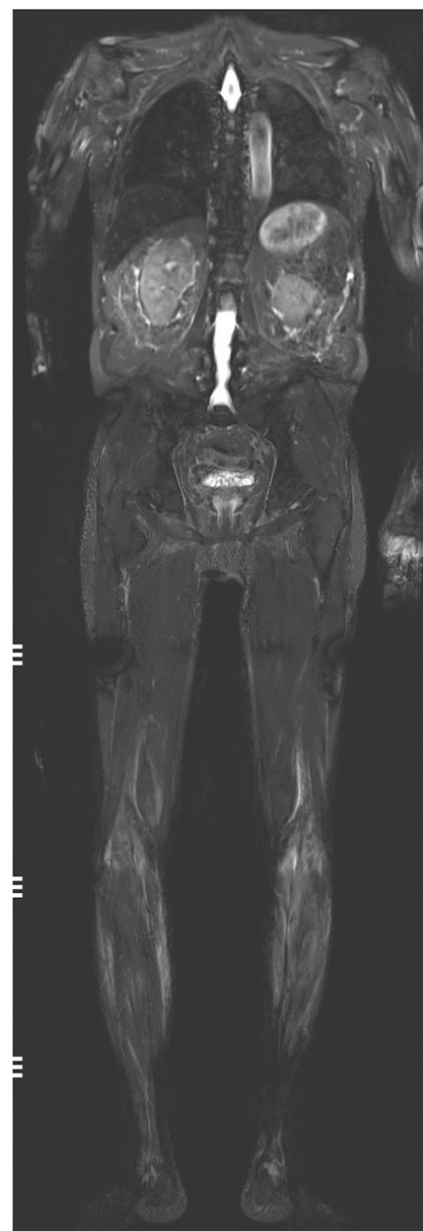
Whole body MRI of a male patient with SSc-myopathy.
